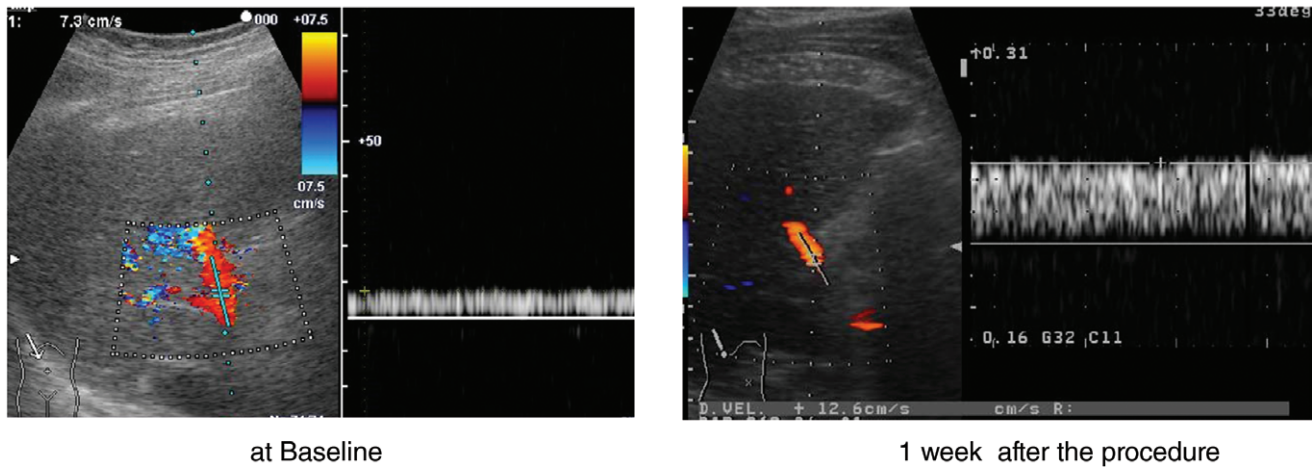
Ultrasound Pulsed Doppler Findings at Baseline and 1 Week after Balloon-Occluded Retrograde Transvenous Obliteration (B-RTO).* a) The velocity of portal venous flow at baseline was 7.3 cm/s, and the flow volume was calculated as 9.7 cm³/s (b) The velocity at 1 Week after B-RTO increased from 7.3 cm/s to 12.6 cm/s, and the flow volume was calculated as 16.7 cm³/s.
